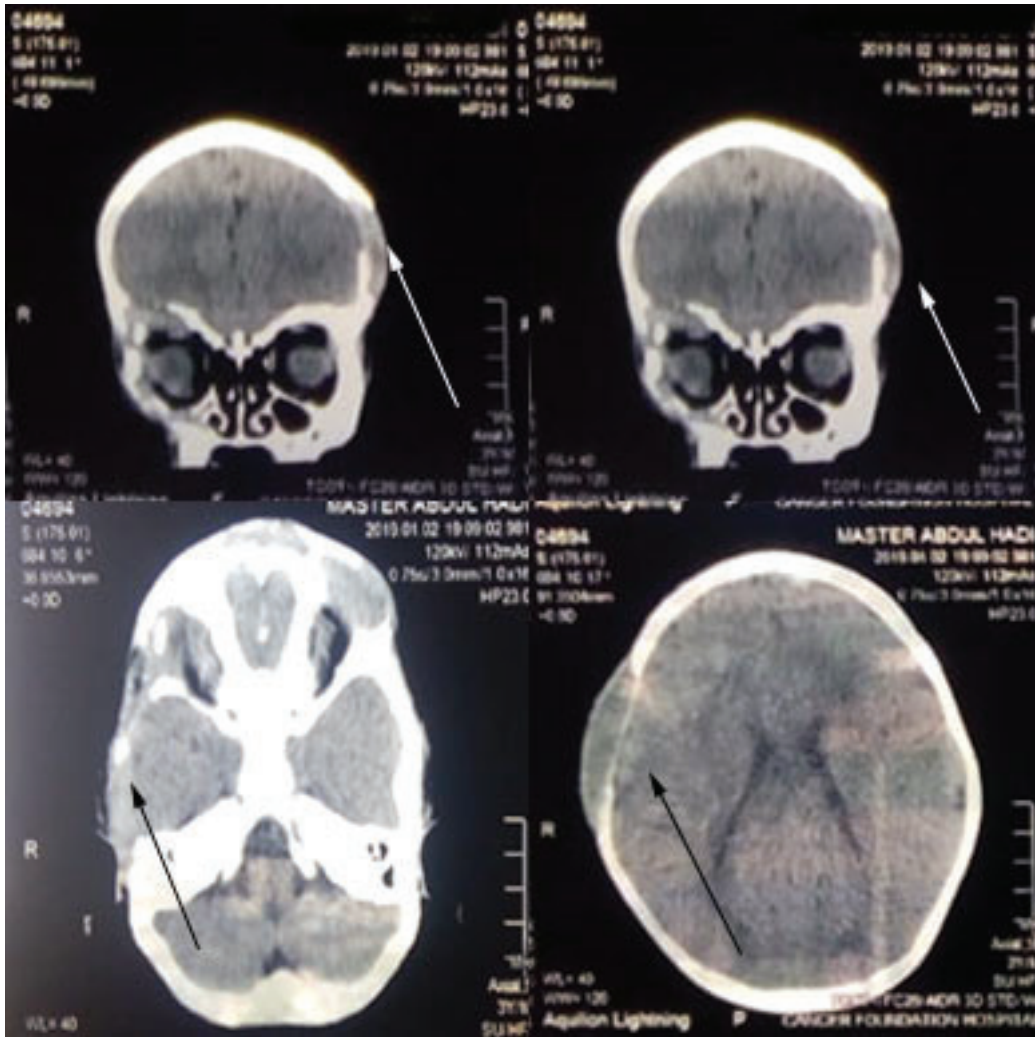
CT scan Brain demonstrates an osteolytic lesion in the right parietal and infratemporal Regions and also left frontal bone small lesion.
